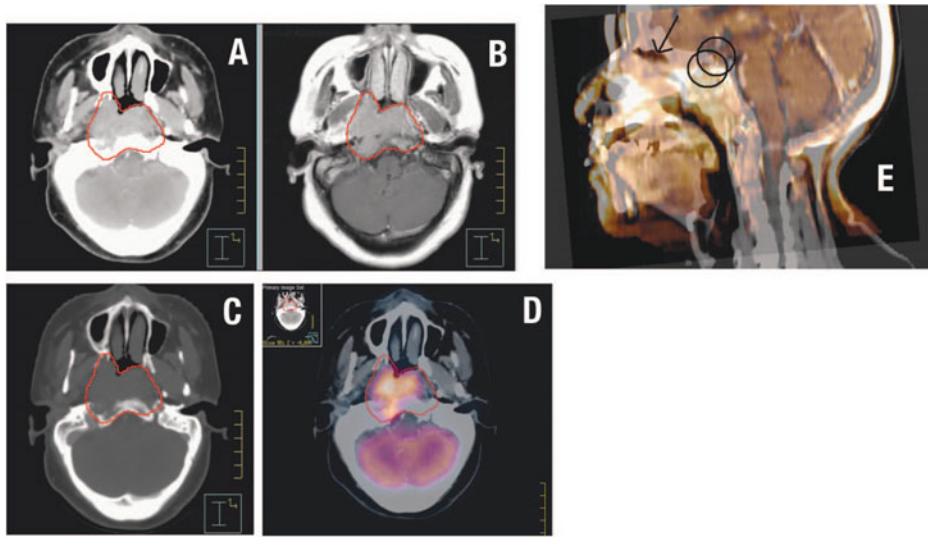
MR and PET Registration/Fusion with Planning CT scan. NPC is contoured. A) Planning CT scan; B) MR registered and fused to planning CT scan; C) Planning CT scan, 'bone' window setting; D) Planning CT scan registered and fused to PET scan; E) Registration/Fusion mismatch error intentionally created to demonstrate inaccuracy in overlay of optic chiasm (arrow points to displacement of chiasm within the circle regions).
